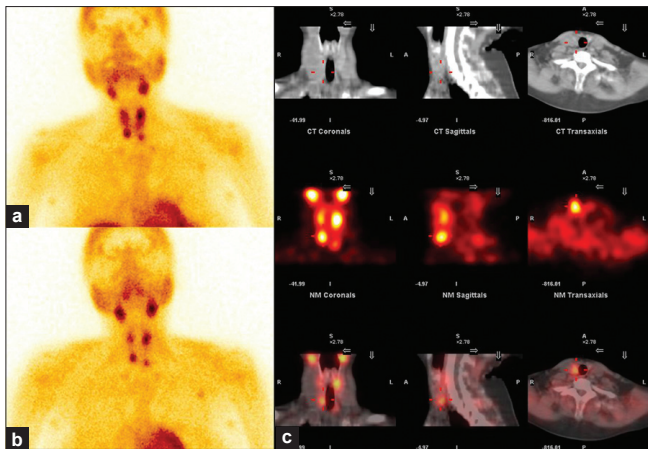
A 44-year-old female presented with severely raised parathormone with USG features showing bilateral parathyroid adenoma with multiple hypoechoic lesions in thyroid gland. Tc99m sestamibi scan (a) early images show increased tracer uptake in the upper and lower poles of the both lobes of the thyroid gland with normal uptake in the other areas; (b) delayed images show retention of the tracer in upper and lower poles of the thyroid gland with washout from other parts. (c) SPECT/CT localizes area of increased tracer uptake to the posterior part of the upper and lower poles of both lobes of the thyroid
